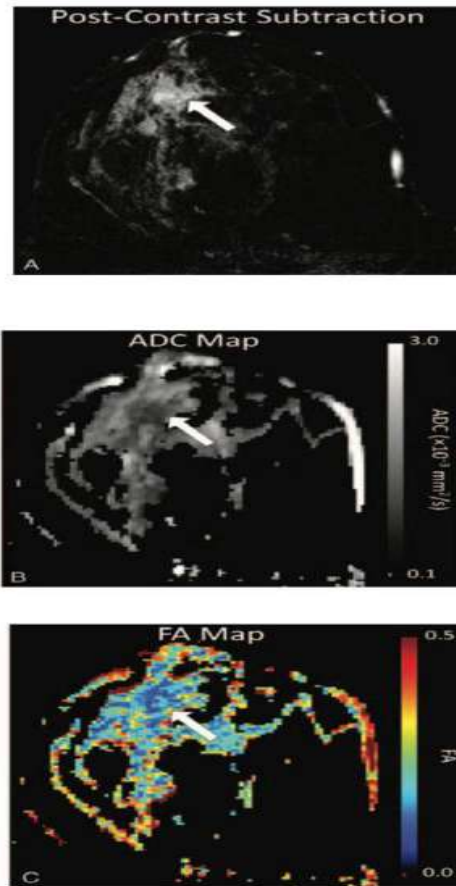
Example of DTI in a 34-year-old woman with invasive ductal carcinoma. Shown are (A) postcontrast T1-weighted subtraction image, (B) ADC map, and (C) fractional anisotropy (FA) map. The enhancing tumor (arrow) exhibits restricted diffusion with reduced ADC ($ADC = 0.94 \times 10^{-3} \text{ mm}^2/\text{s}$) and anisotropy ($FA = 0.12$) versus nearby normal parenchyma, suggesting increased cell density and loss of structured organization [19].
